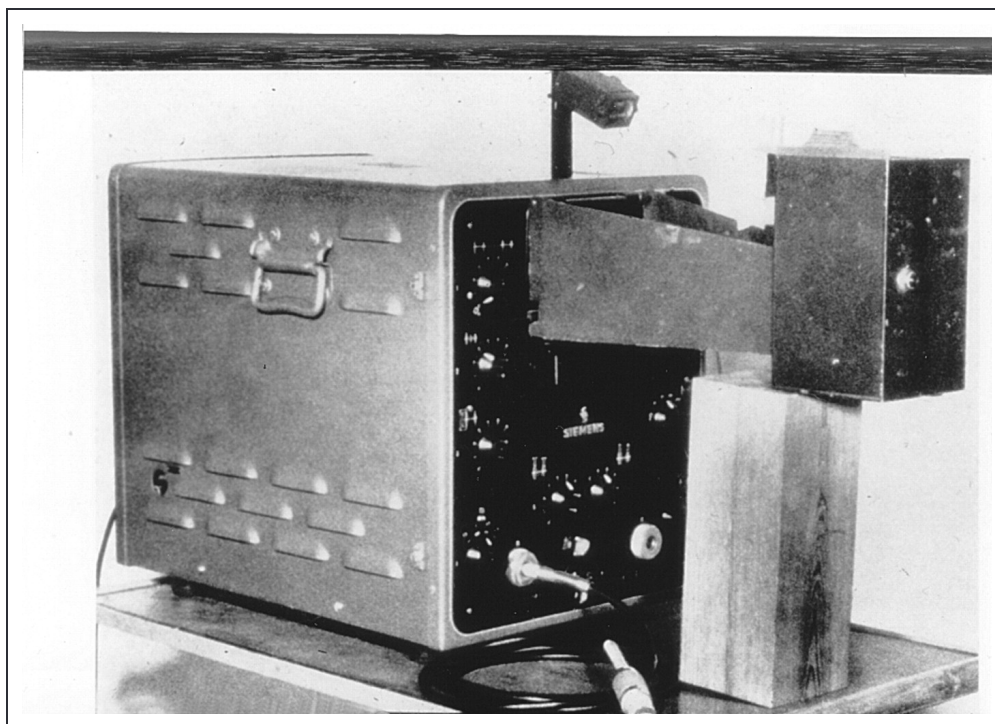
Early echocardiographic equipment used by Edler and Hertz to record M-mode echograms (from Edler et al¹⁷).
